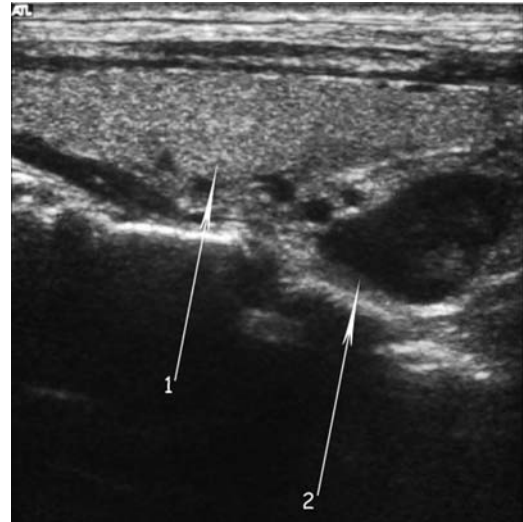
Ultrasonography. Arrow 1: right thyroid lobe. Arrow 2: superior or inferior parathyroid adenoma posterior to the inferior pole of the thyroid lobe.
